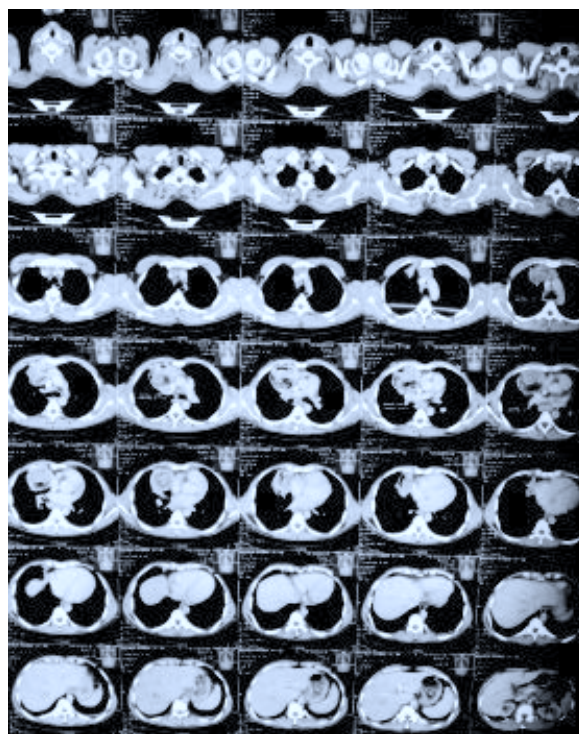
CT scan of chest multi-axial view showing mediastinal mass
